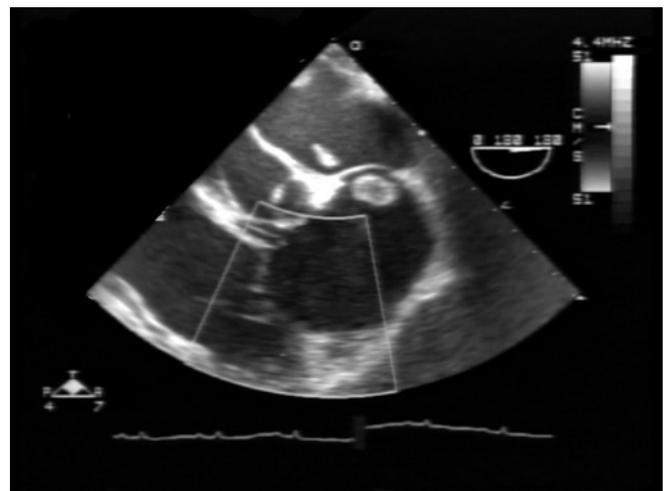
Transesophageal echocardiogram images showing a long thrombus connected by a stalk and projecting through a patent foramen ovale.
